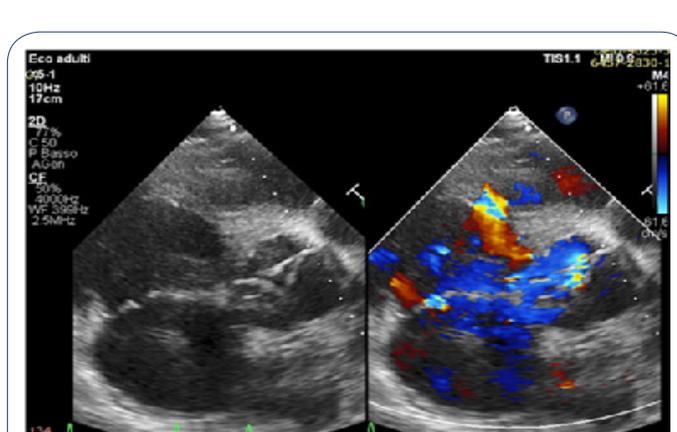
Transoesophageal echocardiographic examination.
